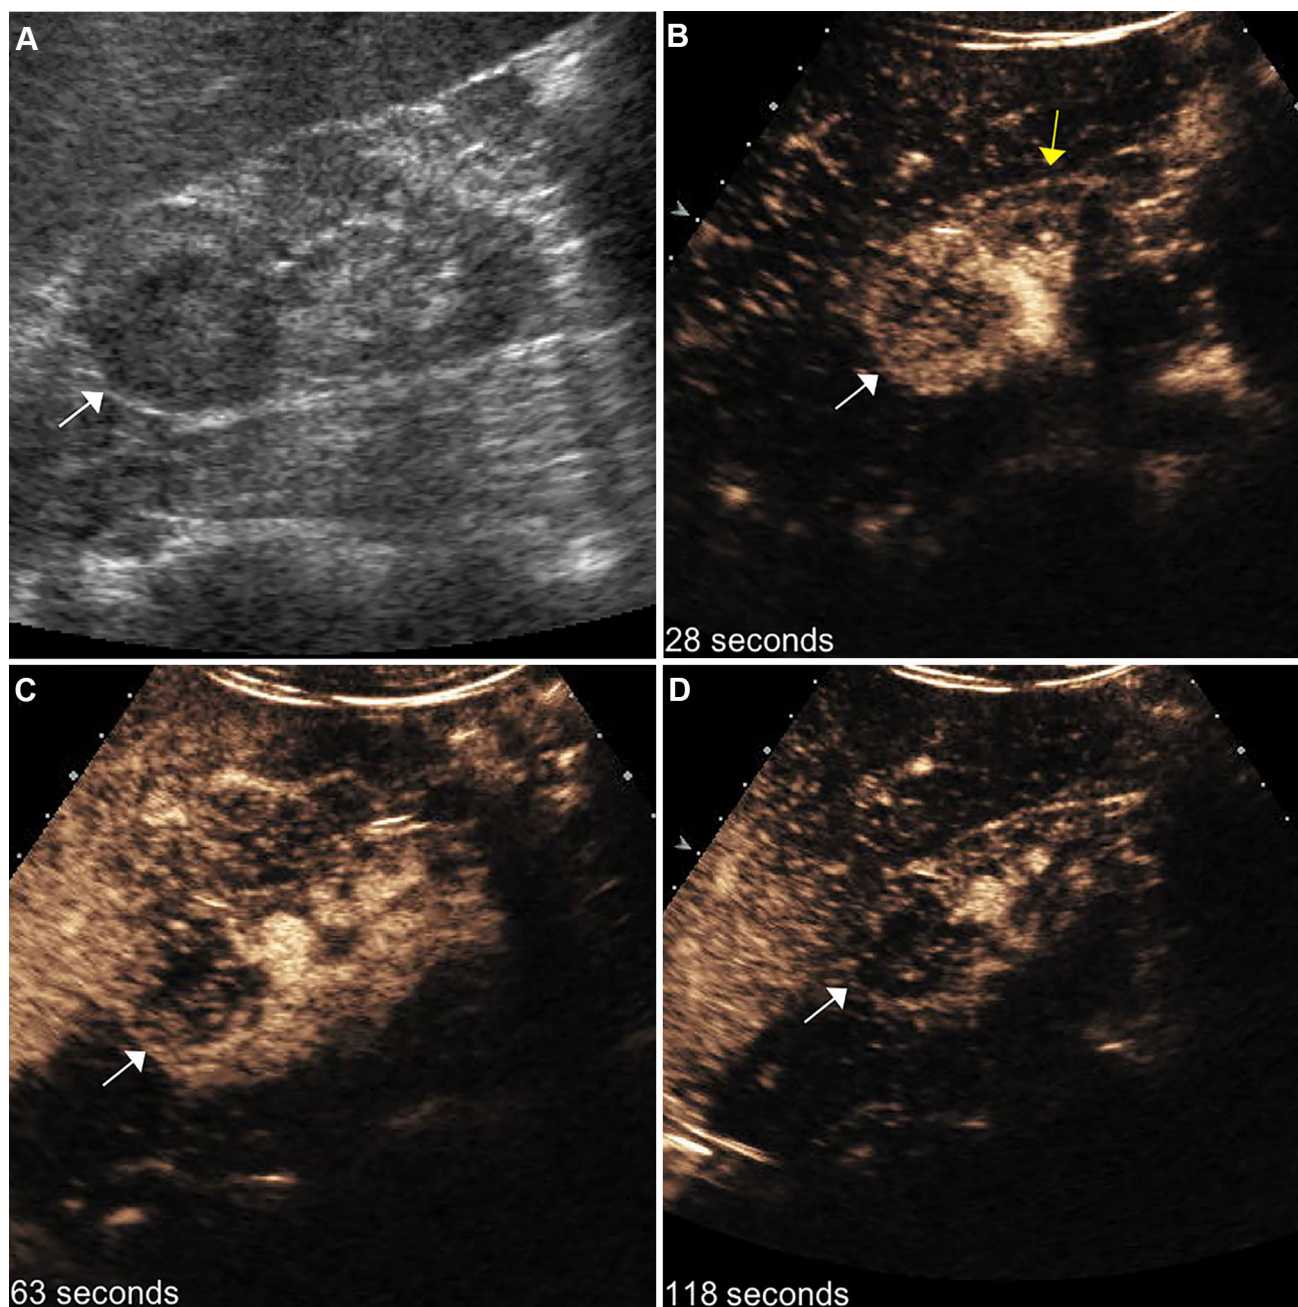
A 51-year-old male with end-stage renal disease (creatinine 5.8) and solid right renal mass detected on non-contrast CT. A Grayscale ultrasound image shows a solid hypoechoic mass at the right renal upper pole (*arrow*). B CEUS in the arterial phase (28 s) reveals early enhancement of this mass (*white arrow*) greater than the background
